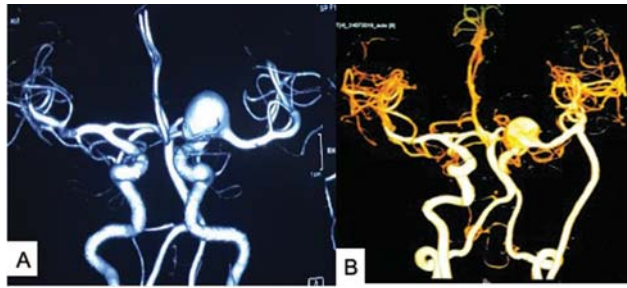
(A) Computed tomography angiography (CTA) of the brain showing left internal carotid artery (ICA) bifurcation large fusiform aneurysm. (B) CTA of the brain just after operation showing disappearance of left ICA, patent extracranial-intracranial (EC-IC) bypass and slightly reduction in size of aneurysm.
